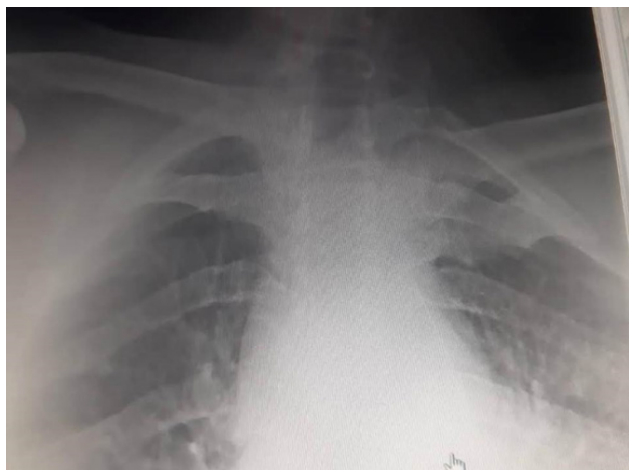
X-ray showing displaced right medial clavicle joint fracture.
